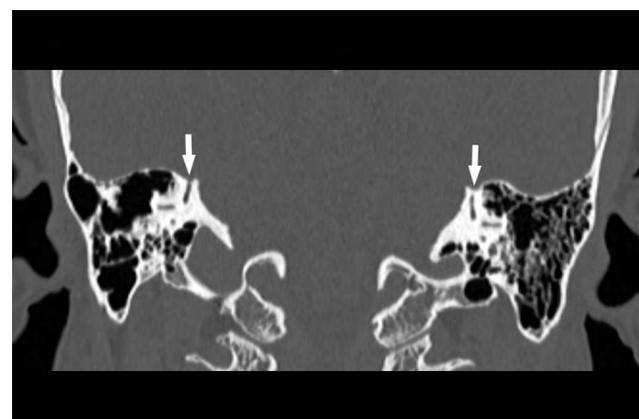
Coronal CT image of a temporal bone at the level of the SSCs shows the defect of the bone coverage of the right SSC, at the level of the groove for the superior petrosal sinus (arrow). The bone coverage of the left SSC at the same level is intact (arrow).
